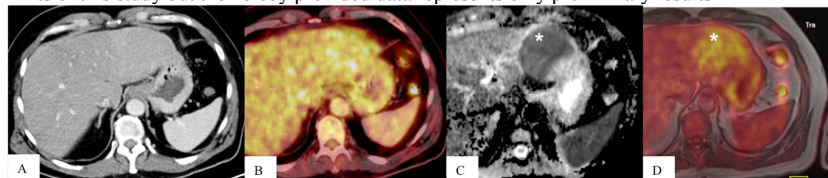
Extranodal involvement of the liver (MALT lymphoma), not recognizable on CT (A) and PET/CT (B) images but well assessable on the ADC map (C) and PET/MR images (D) (asterisks in C and D pointing the lesion).
